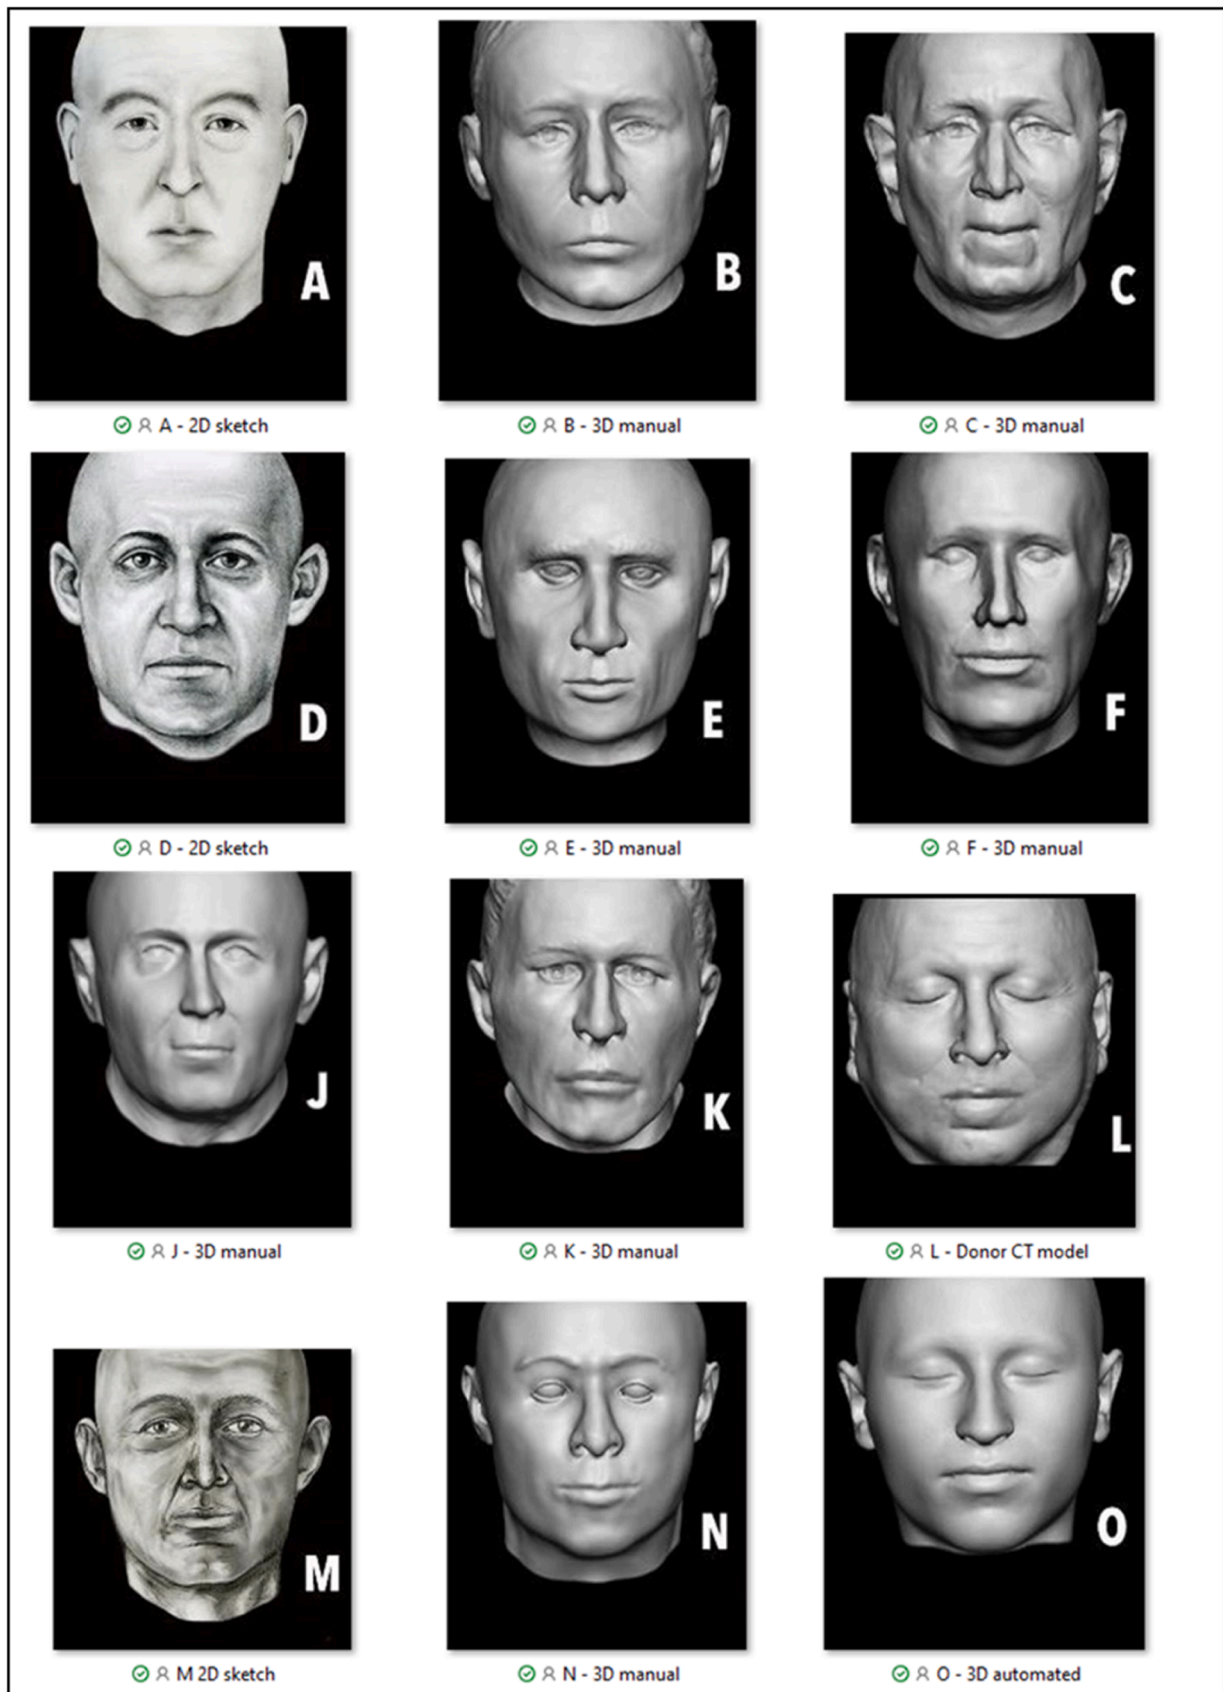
The facial depiction image dataset, including the donor CT model (L).
